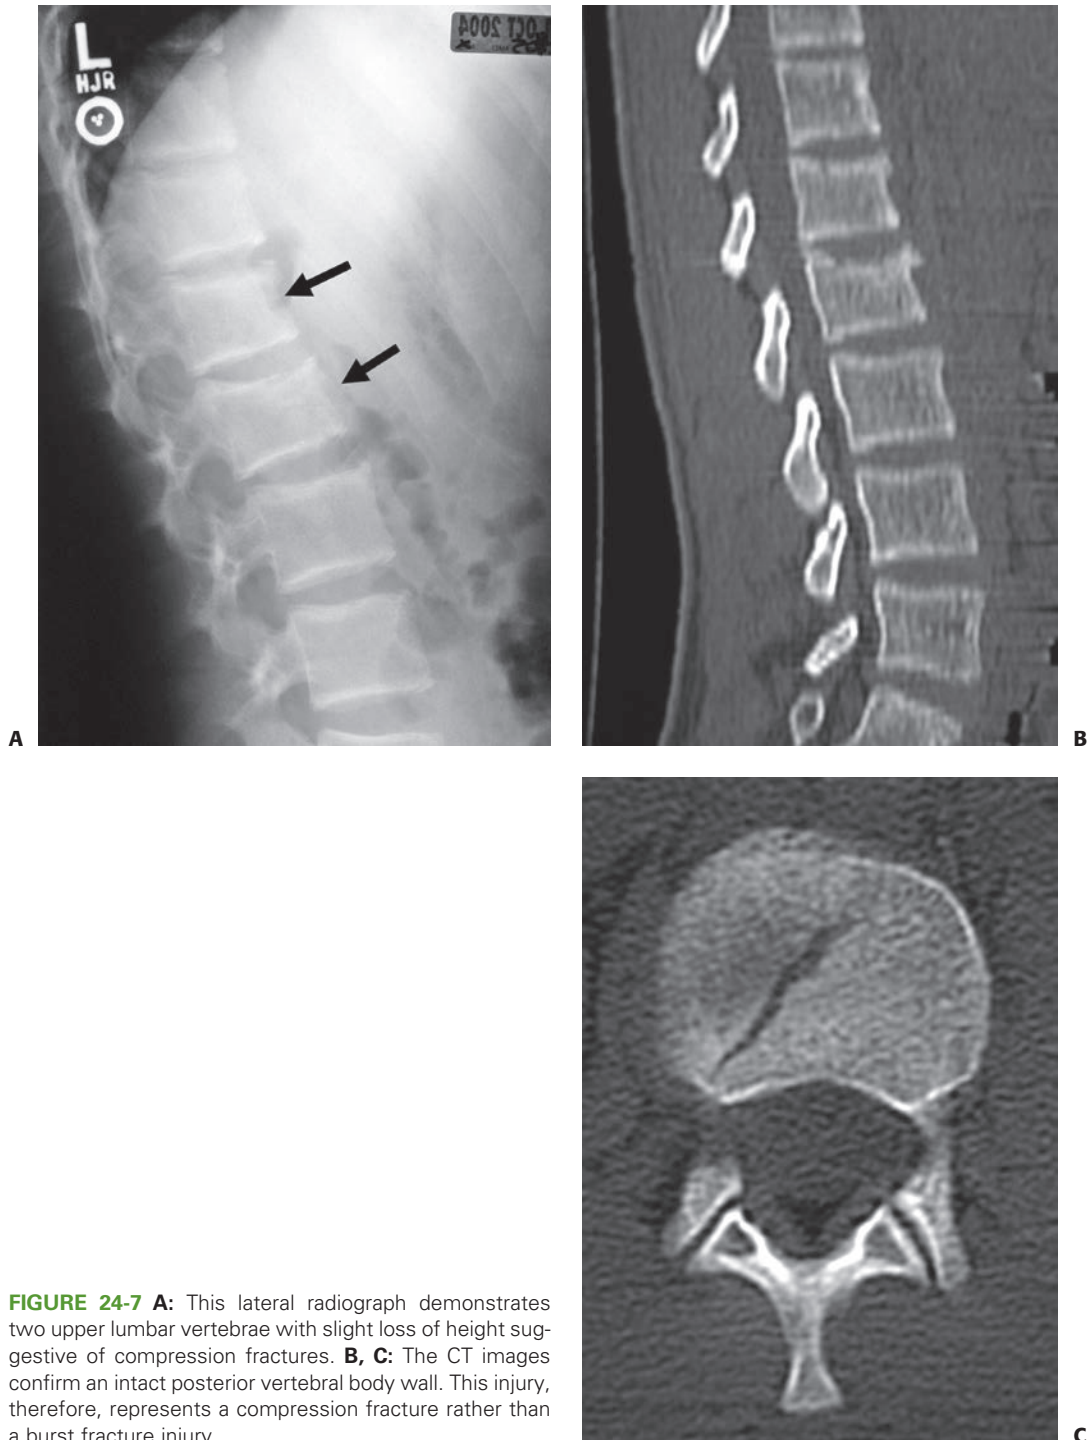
A: This lateral radiograph demonstrates two upper lumbar vertebrae with slight loss of height suggestive of compression fractures. B, C: The CT images confirm an intact posterior vertebral body wall. This injury, therefore, represents a compression fracture rather than a burst fracture injury.
